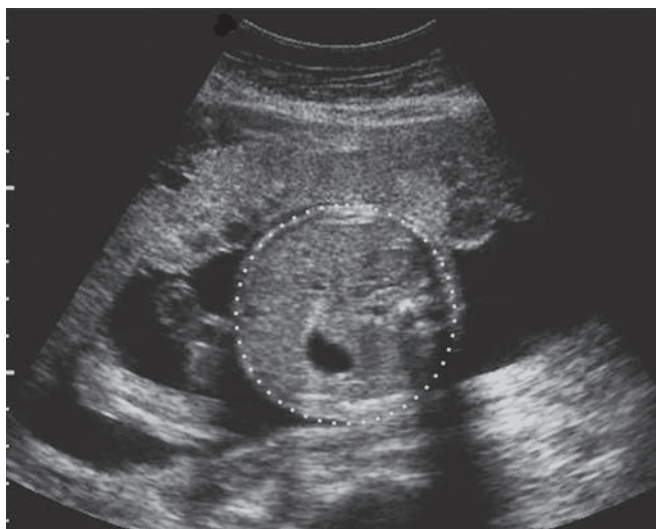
Ultrasound measurement of abdominal circumference
